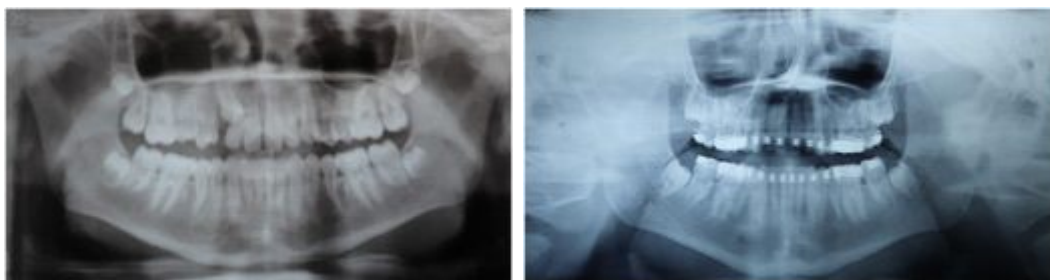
Pre &Post treatment Orthopantomogram
